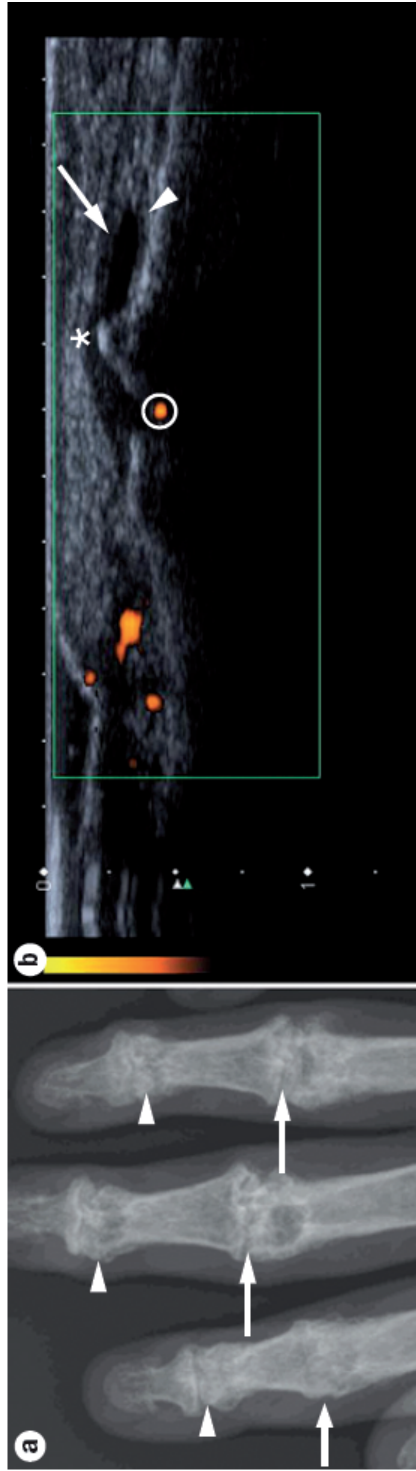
Detection of erosive OA. a: Radiograph shows erosive OA in distal (arrowhead) and proximal (arrow) interphalangeal joints. b: Ultrasound image of distal interphalangeal joint with osteophyte (asterix), effusion (arrow) and synovitis (arrowhead) and power Doppler signal (circled). Abbreviation: OA, osteoarthritis.
